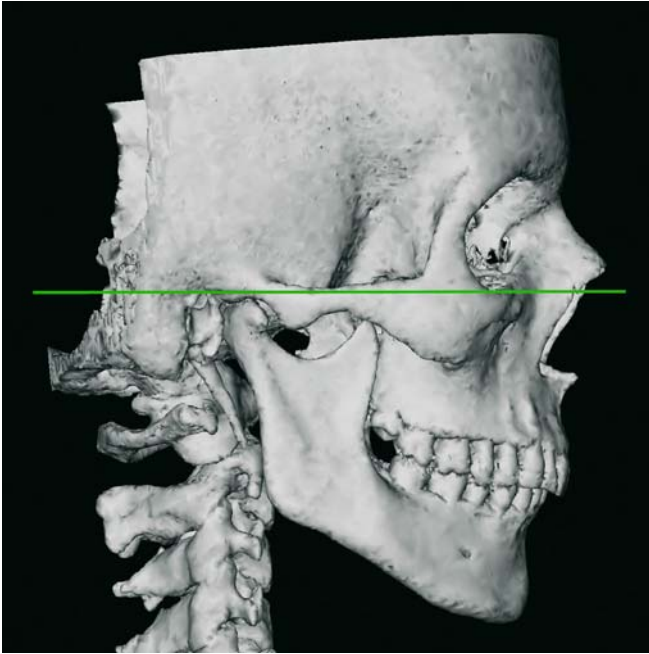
Virtual positioning of the skull parallel to the right Frankfort horizontal (FH) (3-D CT, patient K.C.)
